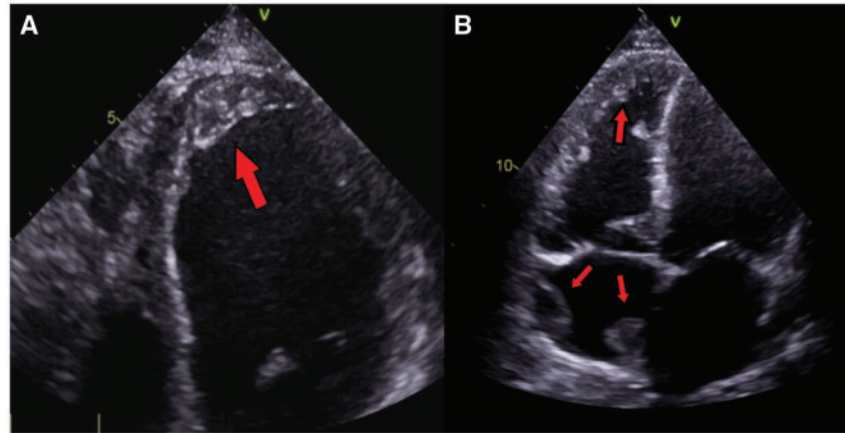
Transthoracic echocardiography showing a mass in the apex of the left ventricle (A) and multiple masses (red arrows) in the right atrium and ventricle (B).
